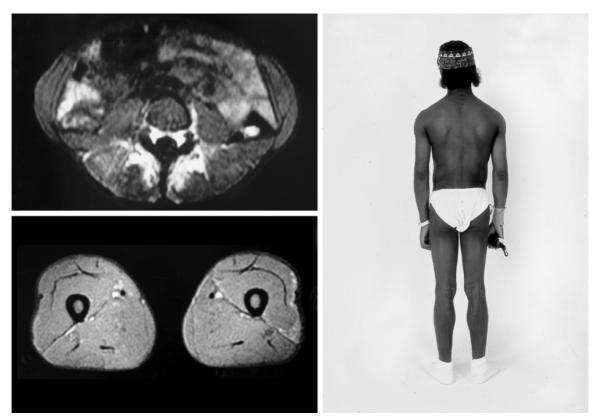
Congenital generalized lipoatrophy in a 16-year old girl. Picture (Right) and T1-weighted magnetic resonance images (Left). Transverse sections of the torso at the level of the fifth lumbar vertebra demonstrate markedly deficient subcutaneous and visceral fat (A). Transverse sections of the midthigh demonstrate absence of subcutaneous, deep, intrafascicular and marrow fat. Note again light-colored, lipid-filled muscle tissue (B). Note absence of fat throughout the body (C). Notice the differences between these images and those presented in Figures 1 and 2.
